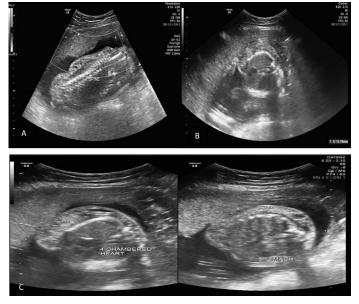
Ultrasound at 23 weeks age of gestation. A. Sagittal view: An avascular, complex mass (labeled with asterisk) at the right thoraco-lumbar region of the fetus; no involvement of the neck. B. Transverse view of the abdomen: cystic structure, partitioned by thick and thin fibrous bands, measuring 13.1 mm, to consider cystic hygroma. C. Transverse view of the fetal chest (*left picture*) and abdomen (*right picture*), showing the location of the mass (labeled with asterisk), at thoracolumbar region; note that there is no extension to the organs adjacent to it.
